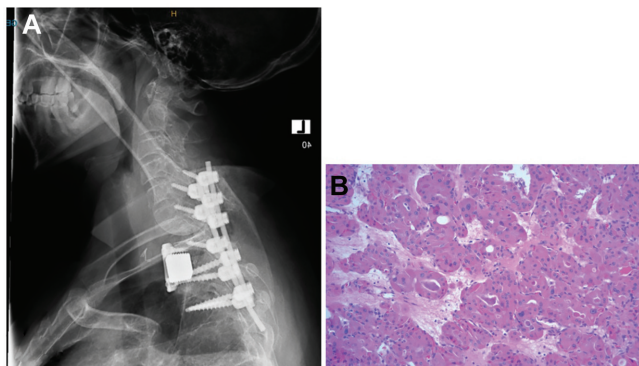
(A) X-ray shows the trabecular metal corpectomy cage and anterior cervical plate for mechanical cervical support and posterior C5-T3 stabilization. (B) Permanent section shows thyroid Hurthle cell adenoma without malignancy, vascular invasion, or cellular atypia.
